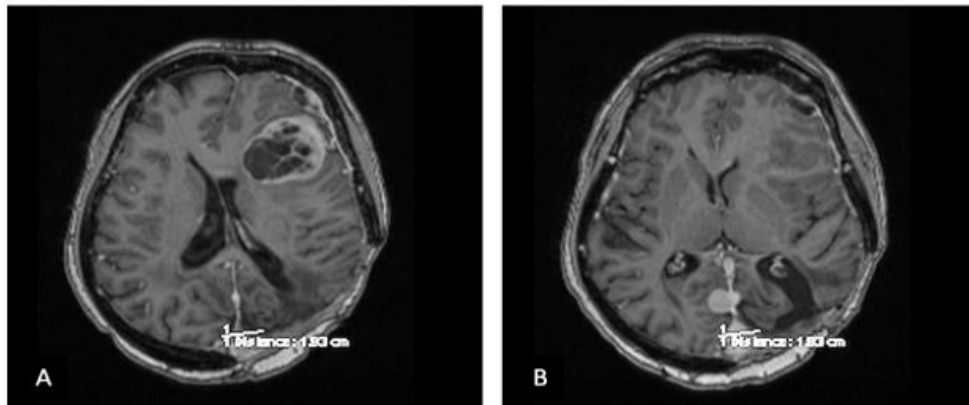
Magnetic resonance imaging (MRI) images of the described case demonstrating multifocal recurrence of intracranial meningeal SFT (A, B)
